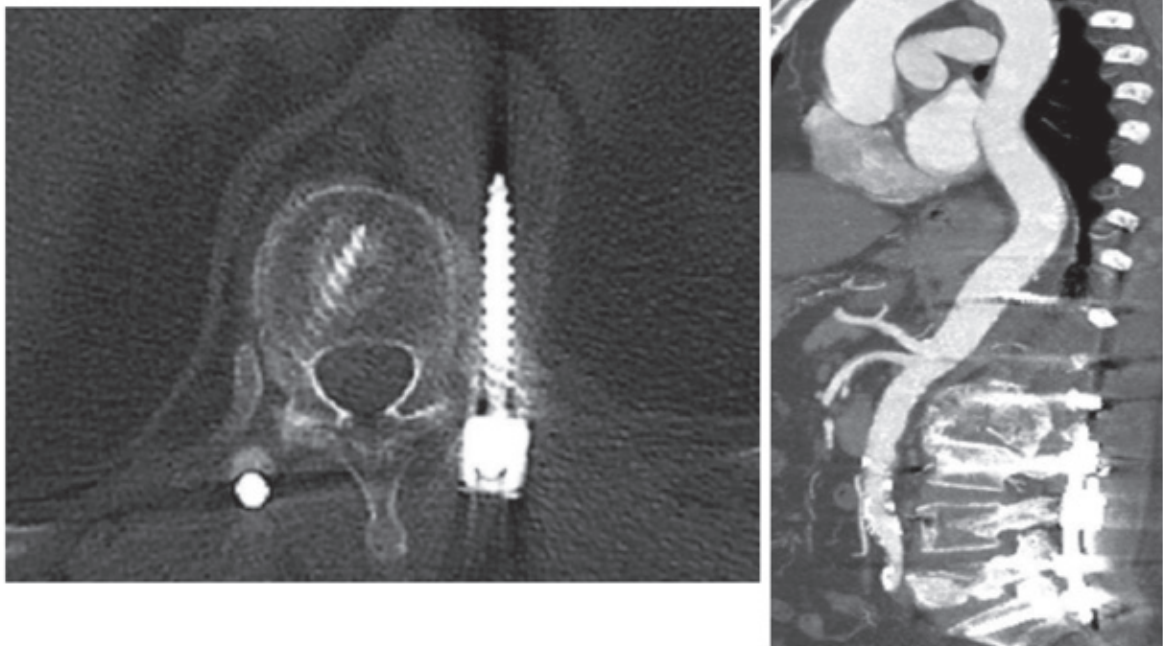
Computed tomography of thoracic spine showing misplaced left pedicle screw in Th 11; computed tomography aortogram showing the tip of the screw penetrating vessel wall.
